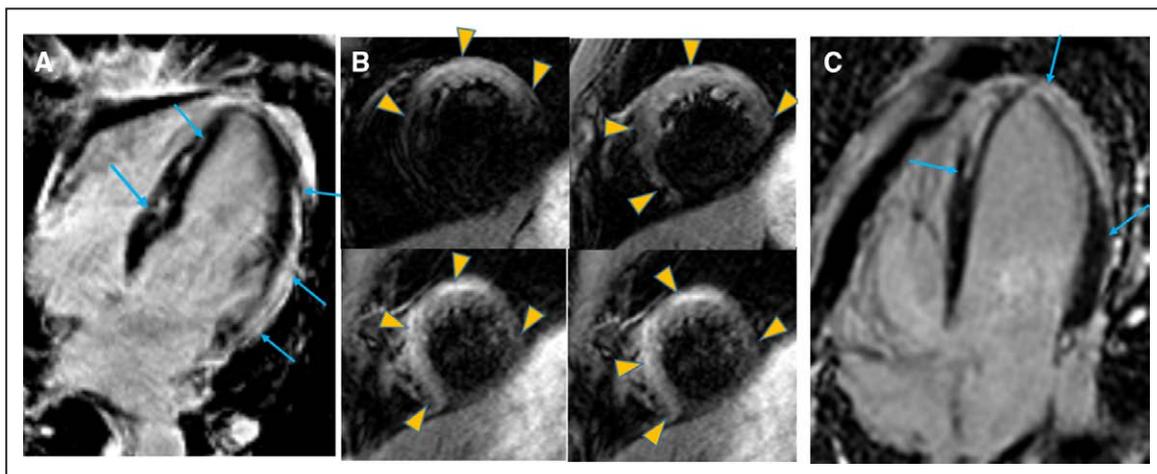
Acute and chronic myocarditis. A and B, Twenty-nine-year old man who presented with acute myocarditis with peak troponin-I 72 ng/mL; peak creatine phosphokinase 2742 U/L, creatine kinase-MB 331 μ g/L. Left ventricular ejection fraction was mildly reduced (Movie I in the [Data Supplement](#)), but he was asymptomatic from the arrhythmia and heart failure standpoint during a 6-d hospitalization. A, Mid-septal and lateral epicardial wall LGE (arrows) and pericardial enhancement. B, T2-weighted edema imaging with extensive edema (arrowheads). He died suddenly at home 2 d post-discharge. C, Twenty-two-year-old patient with documented acute myocarditis 15 mo previously. Cardiac magnetic resonance imaging-late gadolinium enhancement (LGE) showed LGE of the distal segments of the left ventricle (LV) with endocardial sparing (arrows) and pericardium. LV function was normal with no regional wall motion abnormalities (Movie II in the [Data Supplement](#)). Two years later, the patient developed palpitations and syncope with large burden of multifocal premature ventricular contractions on Holter (>5%). Electrophysiology study showed easily inducible monomorphic and polymorphic ventricular tachycardia. An implantable cardioverter defibrillator was implanted and subsequently fired multiple times for monomorphic ventricular tachycardia at 250 bpm.
